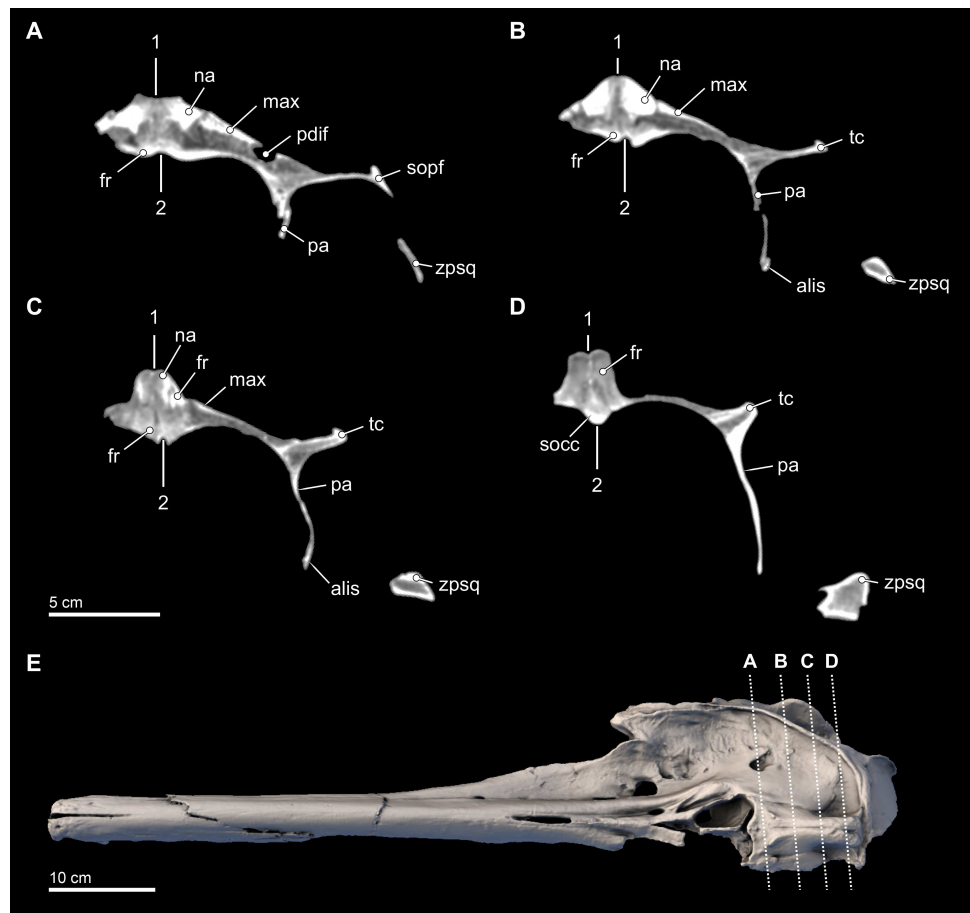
Transverse CT slices through the skull. Computed tomography (CT) slices through the vertex of *Isthminia panamensis* (USNM 546125) across four slightly sub-transverse planes that pass anterior to posterior (A–D). CT slices (A–D) represent respective CT slice numbers 20566, 20625, 20655, and 20708, available for download on the Smithsonian X 3D browser (<http://3d.si.edu>). Numbers 1 and 2 denote facial and endocranial sagittal midlines, respectively, showing the sinistral displacement of the facial bones typical in many odontocetes (Geisler & Sanders, 2003; Mead & Fordyce, 2009).
